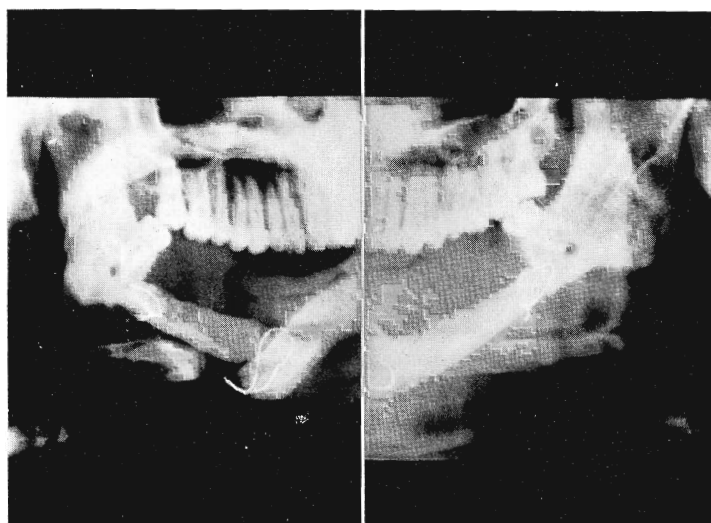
Postoperative Panorex radiograph.
